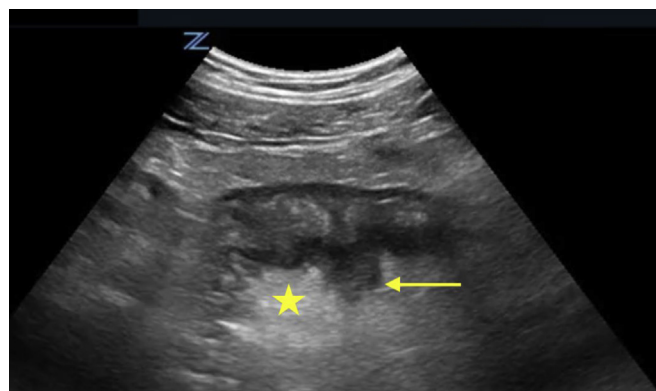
Diverticulitis on ultrasonography. The arrow indicates a diverticulum with associated bowel wall edema. The star indicates pericolic infiltration observed as hyperechoic fat.
